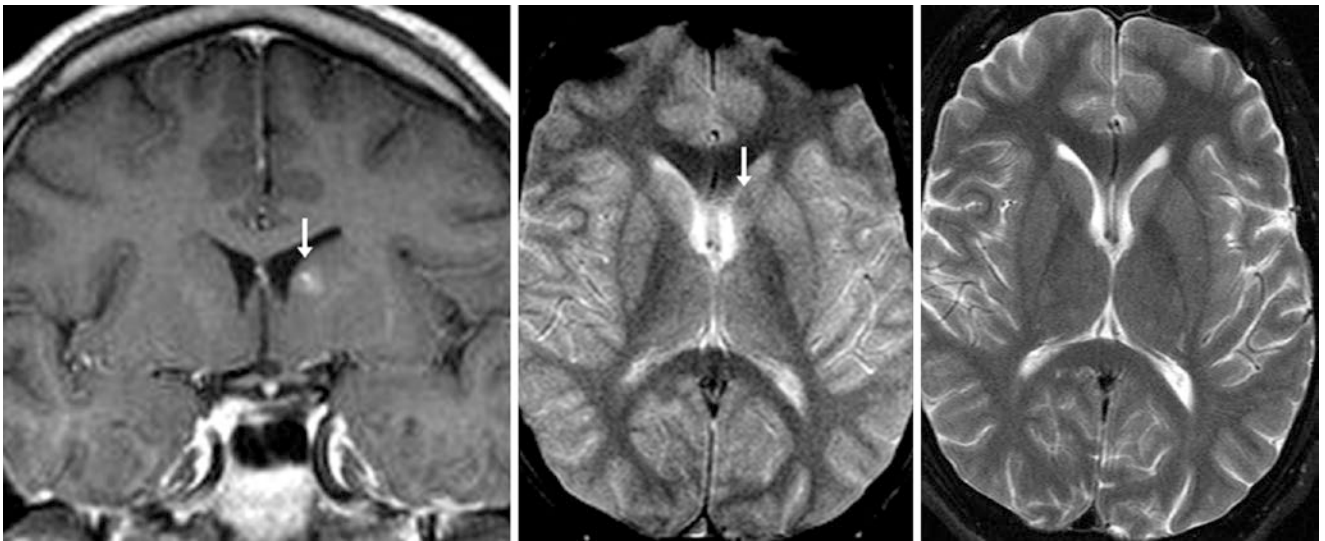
A 27 year old with dizziness; on a 1.5T MRI, there was a region of poorly circumscribed but a moderate degree of enhancement (*arrows*) within the left caudate head on postcontrast coronal SE T1WI
